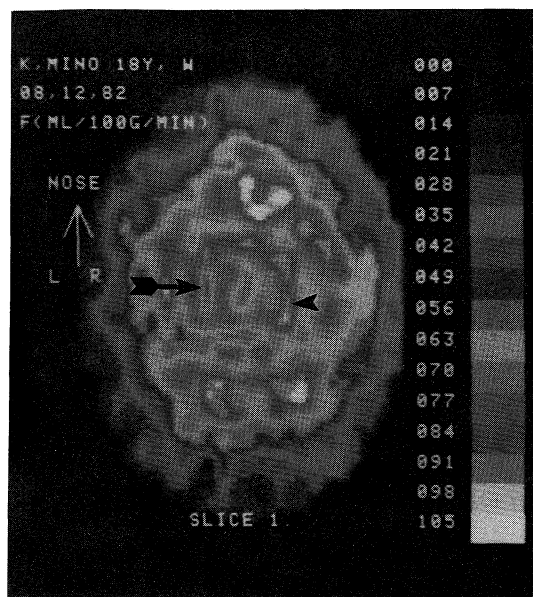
Tomographic rCBF by SPECT with ^{133}Xe inhalation through the plane (3 cm above the orbitomeatal plane, 2 cm thickness). Arrow and arrow head showing rCBF of basal ganglia.
